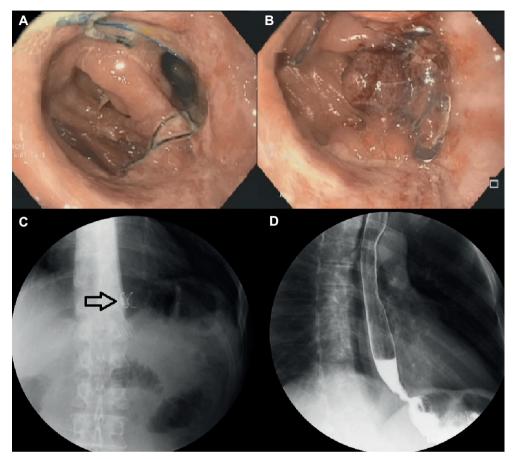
A. Esophagojejunoanastomosis leak endoscopic view. B. Ovesco properly released. C. Radiological control showing evidence of a clip (arrow). D. Absence of contrast medium leakage in x-ray of the digestive tract confirming (Early clinical success). Source: Own authors.
